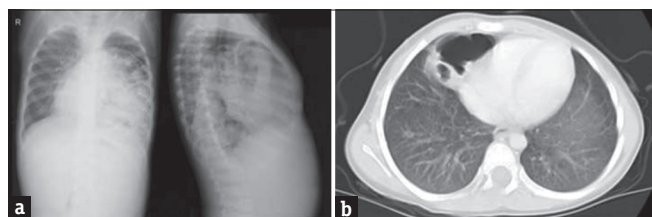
(a). Chest radiograph of a Morgagni hernia (paracardiac opacity), (b). Computed tomography image of a Morgagni hernia
